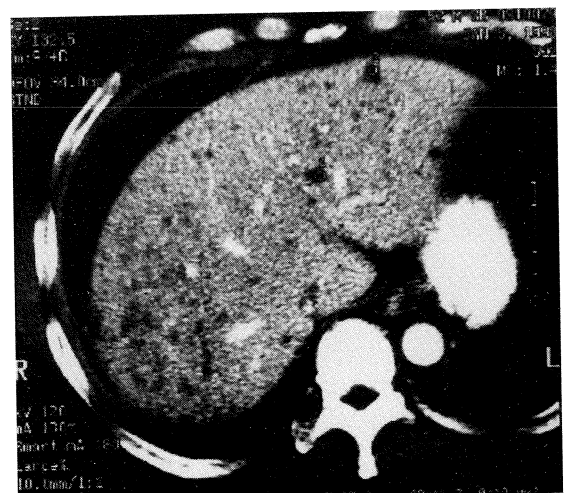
CT scan: Multiple small hypodense nodules.
